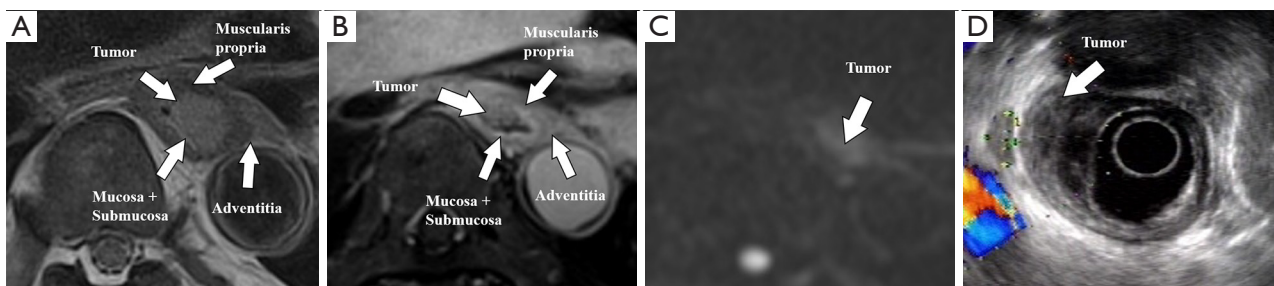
A 68-year-old male patient with T2 esophageal cancer: (A) T2WI BLADE, (B) enhanced T1WI StarVIBE, (C) DWI ($b = 800$), and (D) EUS. The tumor breaks through the submucosa and is limited to the muscularis propria. T2WI, T2-weighted imaging; T1WI, T1-weighted imaging; StarVIBE, stack-of-stars volume interpolated breath-hold examination; DWI, diffusion-weighted imaging; EUS, endoscopic ultrasound.
